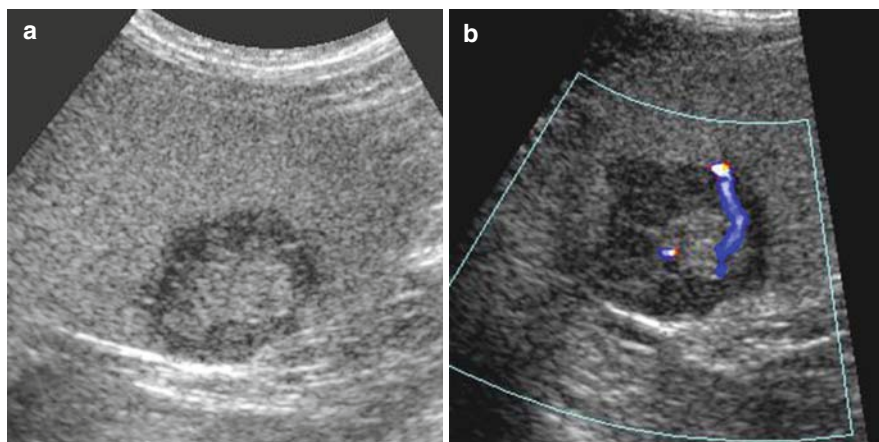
HCC in a 81-year-old man with hepatitis C. (a) US image shows a well-defined hypoechoic mass in the liver. (b) Color Doppler US image shows a linear intratumoral vessel showing arterial flow on spectral Doppler examination (not shown).
